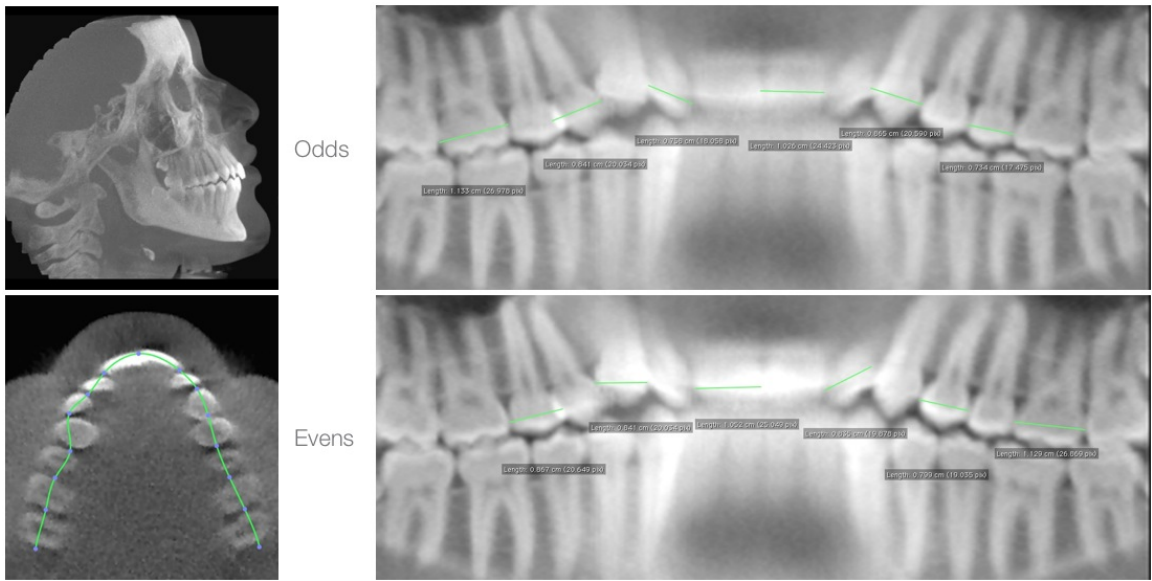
Method 2: CBCT Detailed Pano - OsiriX (Maxilla).
